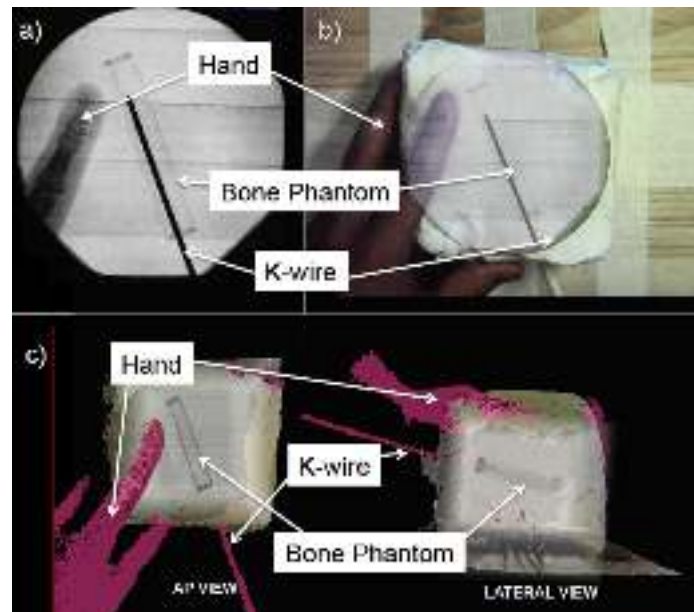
The three visualization compared in the preclinical study. (a) Conventional X-Ray systems, (b) Camera augmented mobile C-arm system, and (c) Mixed reality visualization system proposed in the thesis Sources: images are taken from [10]
